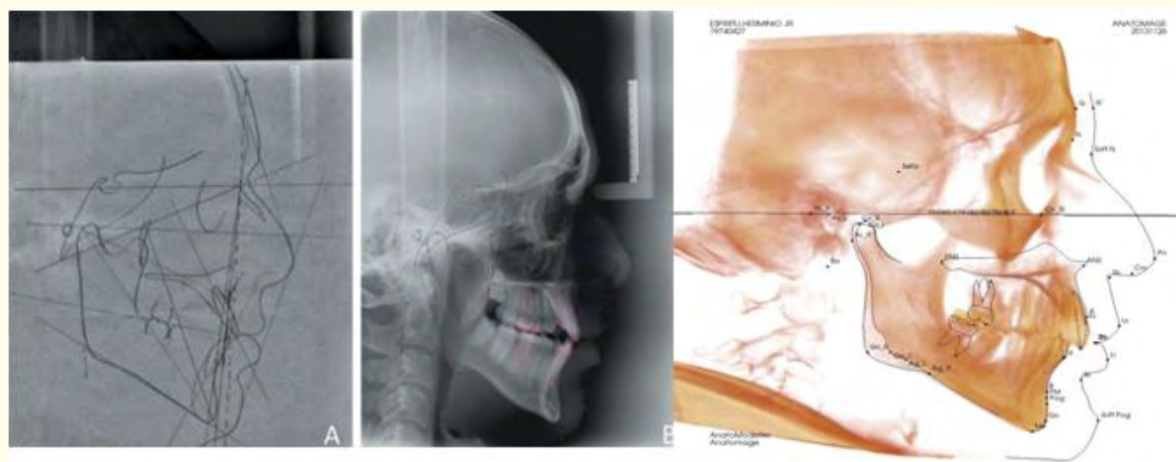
Hand, Dolphin and CBCT tracings.
